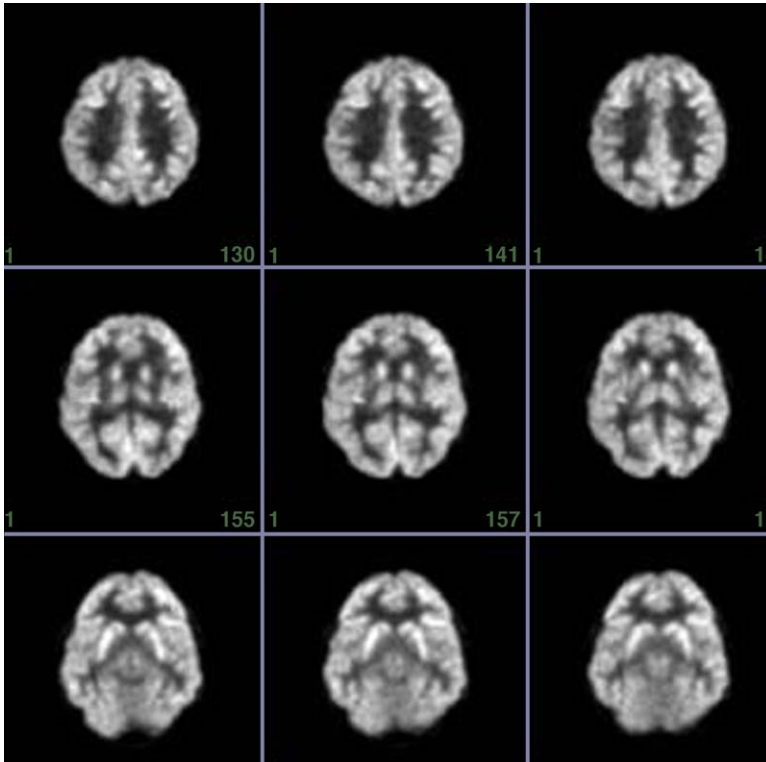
FDG-PET image of normal subject using a high-resolution gadolinium orthosilicate PET camera. The resolution of 2.5 to 3mm is superior to prior PET cameras and demonstrates significant cortical and subcortical detail.
